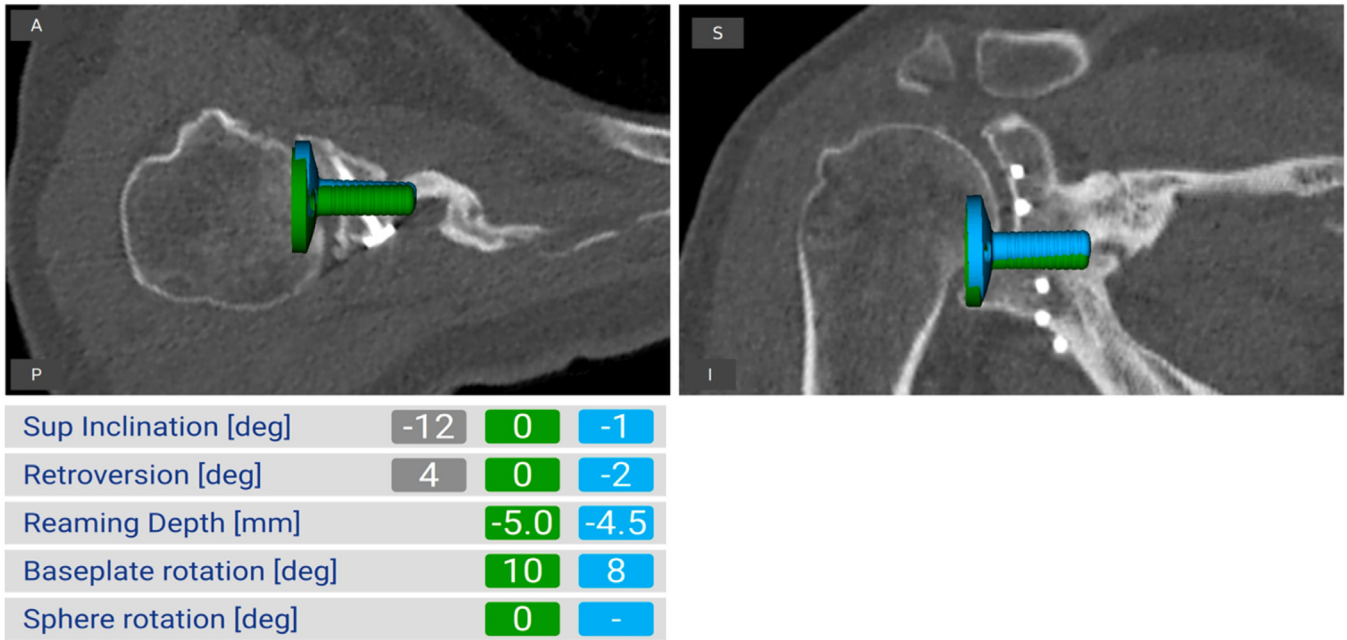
CT scans with superimposed glenoid baseplate, where green represents templated position and blue represents implanted position. This color code is also used to compare preoperative and postoperative measurements (inclination, retroversion, reaming depth, and baseplate rotation). CT, computed tomography.
